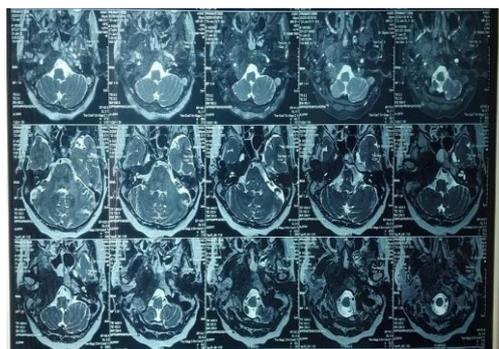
MRI of Brain with temporal bone
